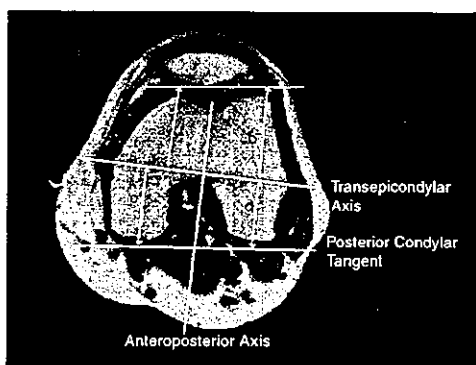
Magnetic resonance image of the axial view of the distal femur. A line was drawn perpendicular to the transepicondylar axis from the most anterior part of each anterior condyle. The distance (a) was defined as AP dimension of the anterior part of the medial femoral condyle and the distance (b) was defined as that of the lateral femoral condyle. A line was drawn perpendicular to the transepicondylar axis from the most posterior part of each posterior condyle. The distance (c) was defined as the AP dimension of the posterior part of the medial femoral condyle and the distance (d) was defined that of the lateral femoral condyle.
